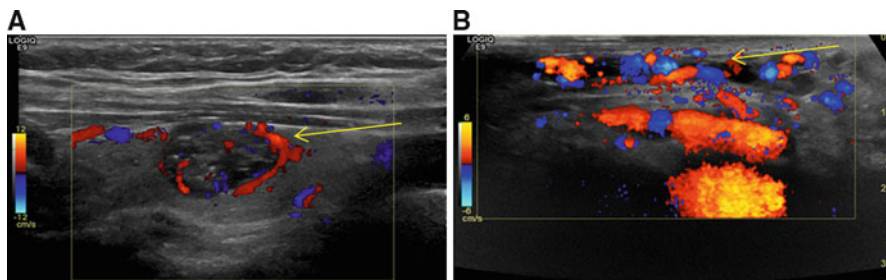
Doppler imaging. (a) Color Doppler imaging demonstrates flow (*arrow*) within a solid thyroid nodule. (b) Color Doppler imaging demonstrates flow (*arrow*) within the pampiniform plexus of the male spermatic cord
